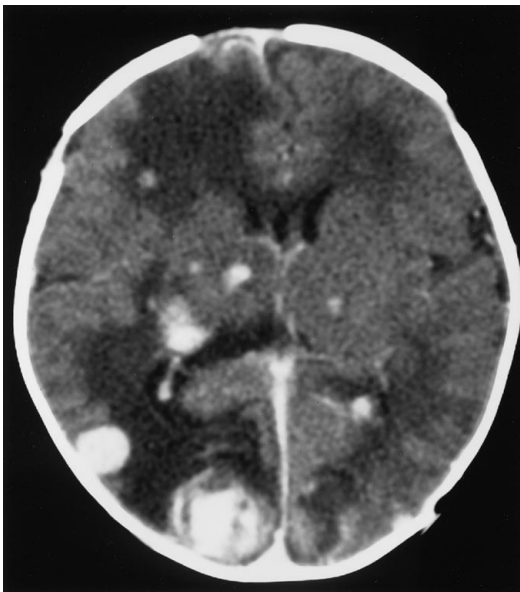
Enhanced axial CT scan of the brain demonstrates multiple hyperdense hemorrhagic lesions consistent with hemangiomas, as well as extensive edema within the right frontal and right parietooccipital lobes
